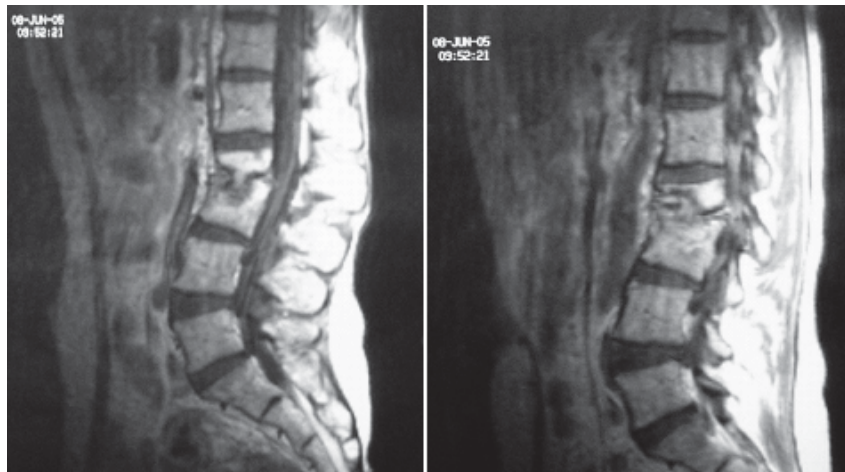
Magnetic resonance imaging of the lumbar spine 2 months after antibiotic treatment cessation.
